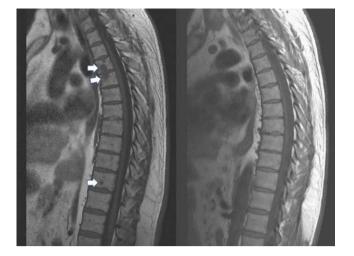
Sagittal T1 weighted, non-fat suppressed magnetic resonance imaging showing multiple hypo-intense lesions in thoracic spine before treatment (left, see arrows) and 2 y after treatment with anti-tumor necrosis factor inhibitor (right). Note: resolution of osseous sarcoid lesions post-treatment
